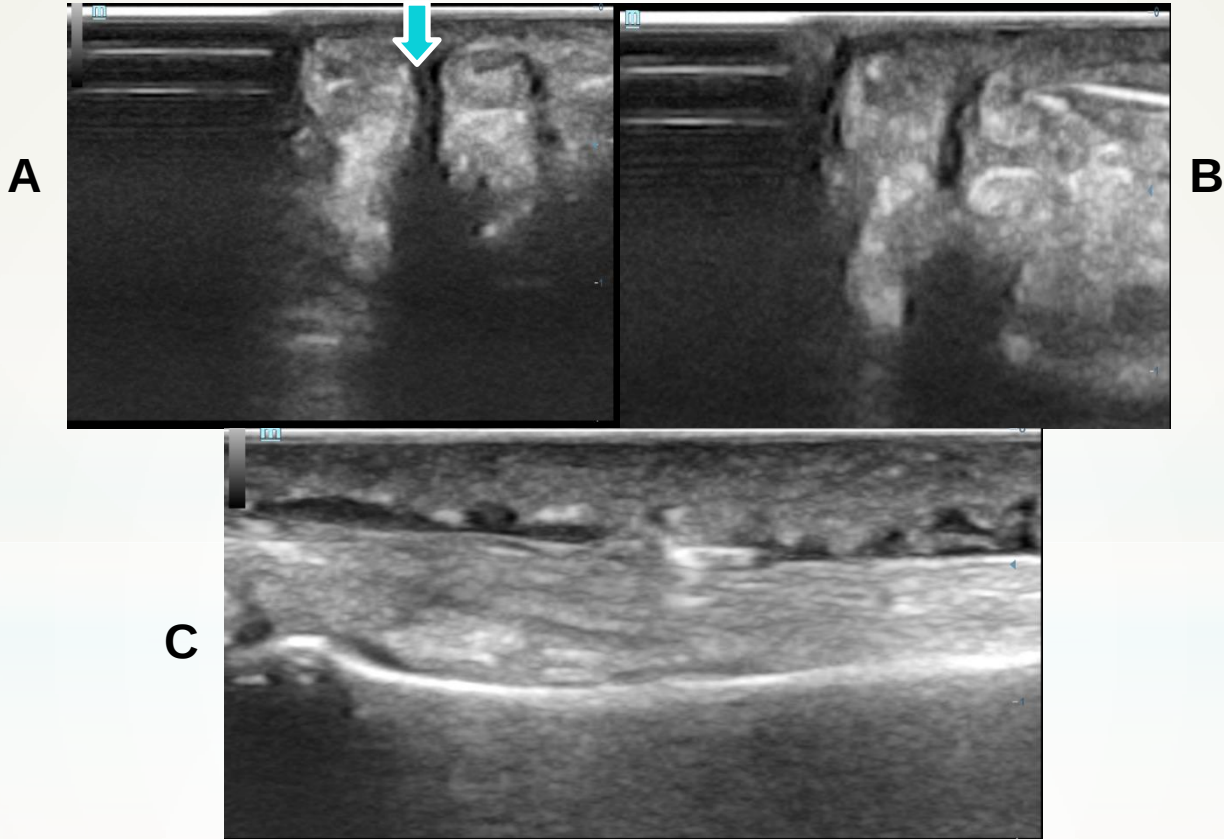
a) Axial ultrasound view of the flexor tendon of the right little finger surrounded by thickened A1 pulley. Dark blue arrow showing thickened A1 pulley, b) Axial ultrasound view showing injection of steroid into the tendon sheath, c) Longitudinal ultrasound view after steroid injection.
